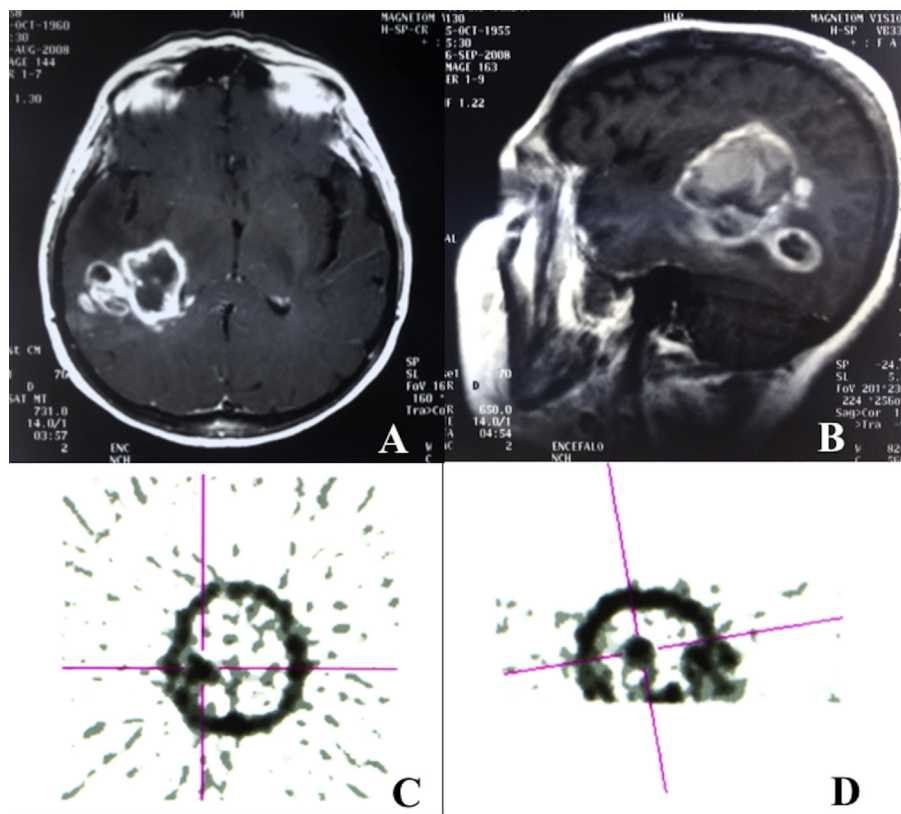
(A) Magnetic resonance imaging (MRI) study shows an irregularly hypointense lesion localized in the right temporo-parietal region. The lesion appears surrounded by a peripheral, thickened, enhanced wall after gadolinium administration. (B) A new MRI study, carried out a few days after ^{99m}Tc -Leukoscan, demonstrates an additional hypointense mass with a ring-like enhancement suggestive for a rapid evolution of the infectious hotbed. (C) Tomographic scans (magnification 1, matrix 128x128; 180° rotation, a 3° step, and shoot technique; 30 seconds per frame): axial sections of the brain. Images show a definite area of abnormal and nonhomogeneous uptake of the tracer in the right temporo-parietal region (red cross-bar) consistent with brain abscess. (D) Tomographic scans (magnification 1, matrix 128x128; 180° rotation, a 3° step and shoot technique; 30 seconds per frame): sagittal sections of the brain. Images show a definite area of abnormal and nonhomogeneous uptake of the tracer in the right temporo-parietal region (red cross-bar) consistent with brain abscess.
